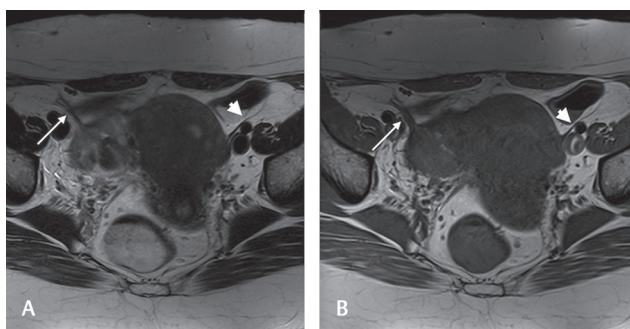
(A, B) T2W (A) and T1W (B) axial images showing a normal thread-like round ligament on the left side (*arrowhead*) and a thickened ligament on the right side (*arrow*). T1W, T1-weighted; T2W, T2-weighted.
